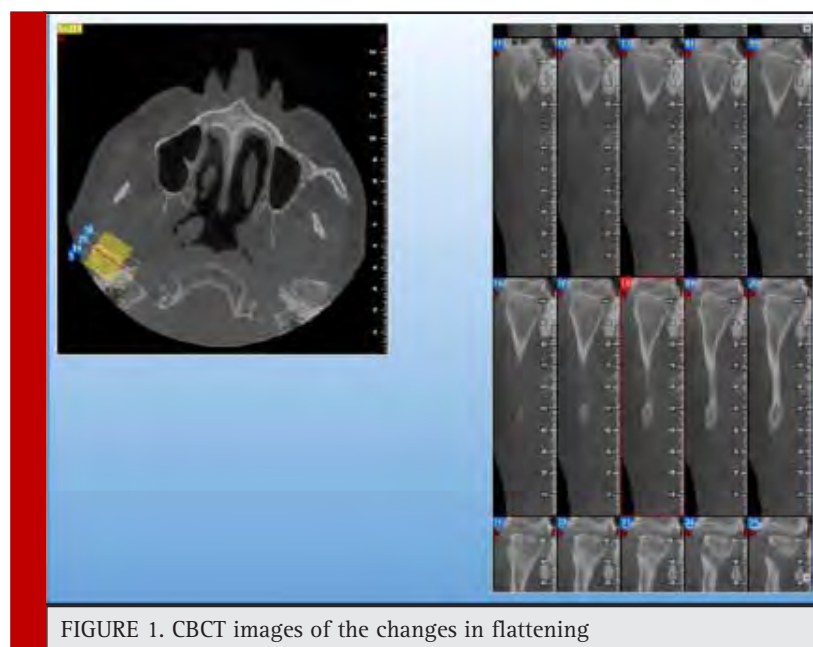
CBCT images of the changes in flattening
